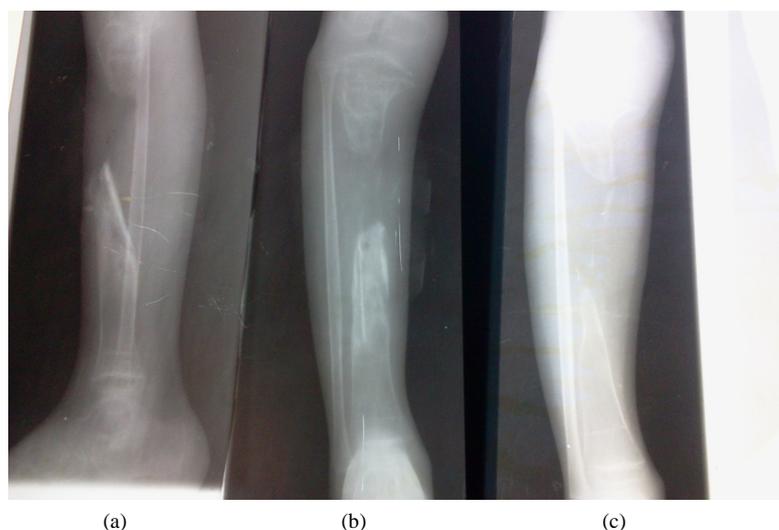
(a) and (b): Presenting radiograph before repeat sequestrectomy: shows an intact fibula, Gap-non union, proximal tibia physis haziness, osteopenic bones and sequestrum. (c): 3 months post repeat sequestrectomy radiograph shows good infection control and no sequestrum.
